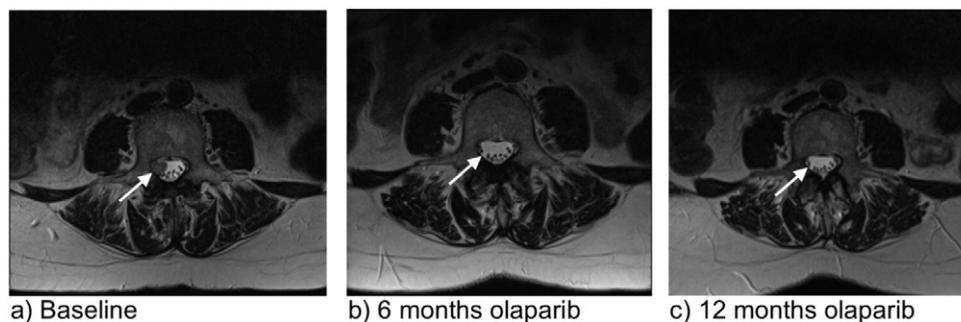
MRI spine scans demonstrating complete resolution of leptomenigeal disease at the L4 vertebral level with olaparib treatment (T2 weighted, axial sections). a) Enhancing leptomenigeal disease at the L4 vertebral level prior to olaparib. b) Normal appearances at the site of the previous spinal leptomenigeal disease after 6 months of olaparib. c) Normal appearances at the site of the previous spinal leptomenigeal disease after 12 months of olaparib.
